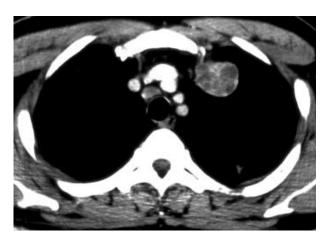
Contrast-enhanced CT of the chest shows a well-circumscribed nodule composed of clustered cysts in the left upper lobe.
